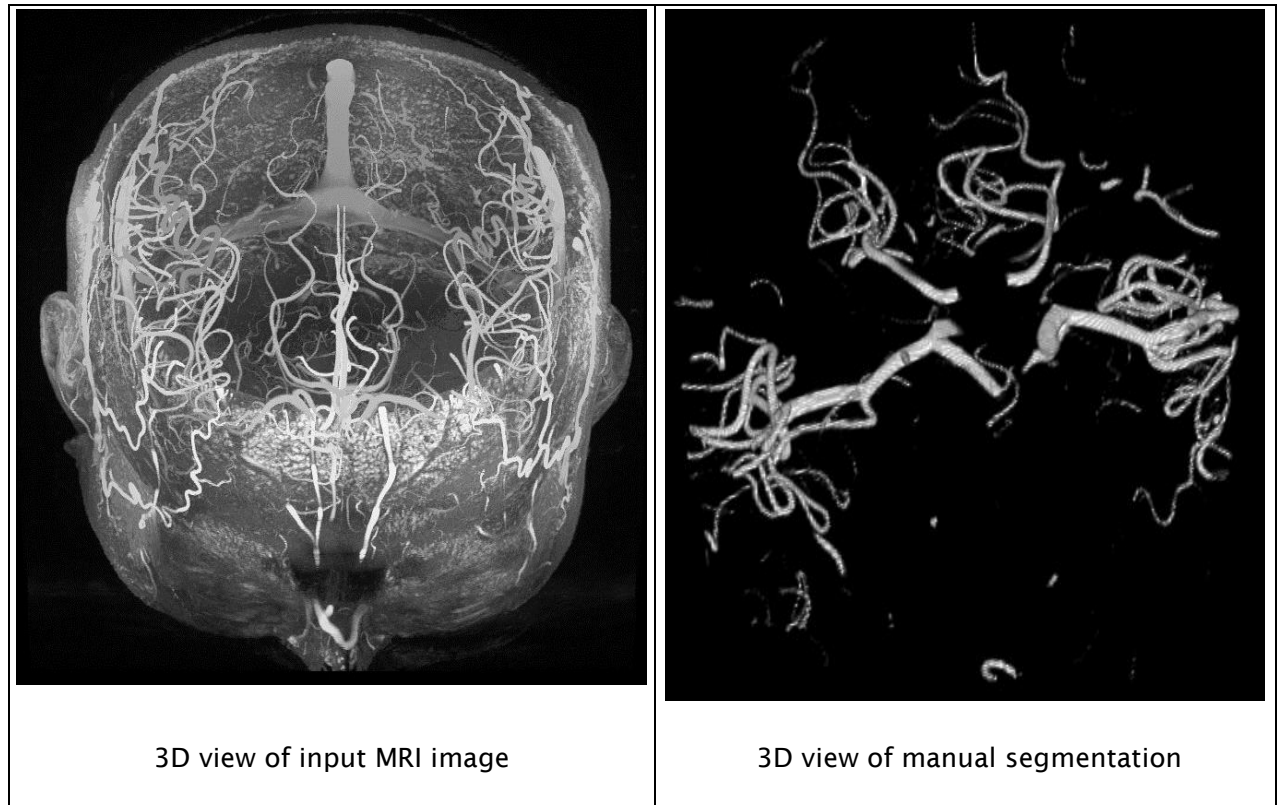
3D view for 3D MRI images
